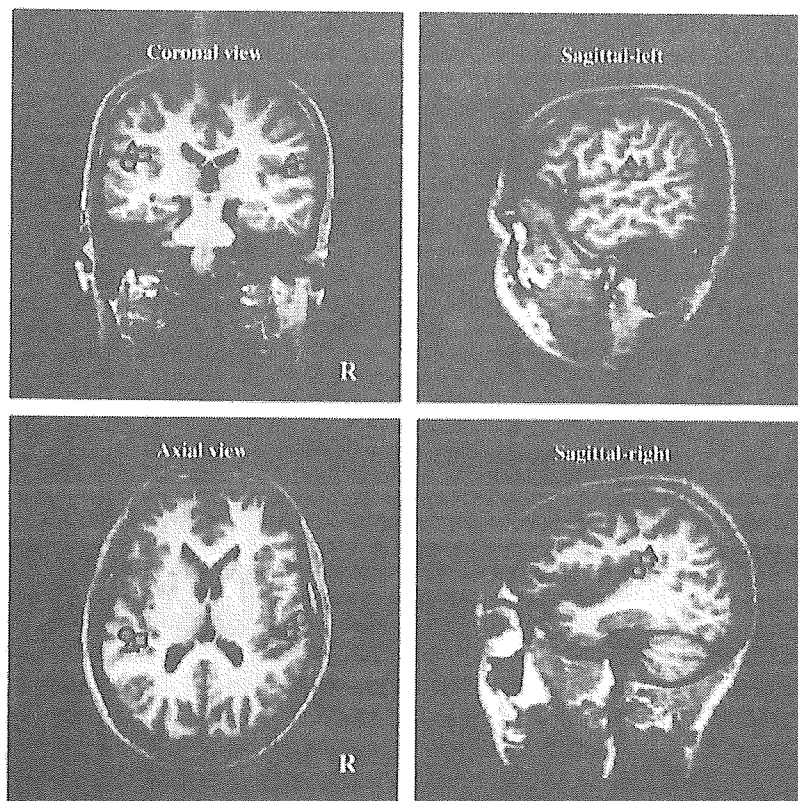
Locations of equivalent current dipoles (ECDs) under each condition in each hemisphere of a control subject superimposed on a magnetic resonance imaging slice of this subject. Circle: ECD location of MMF under tone-duration condition; triangle: that under phoneme-duration condition; and square: that under across-phoneme condition.
